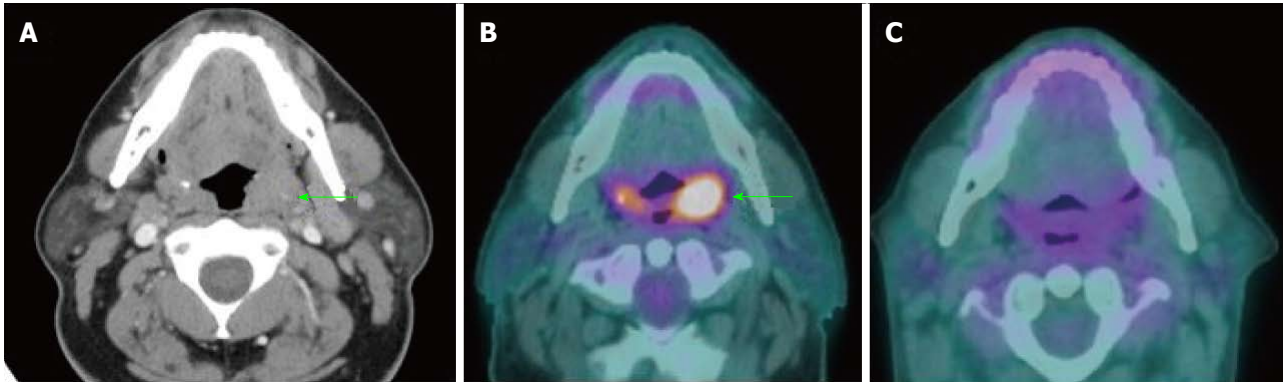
Complete treatment response at primary tumor site. Squamous cell carcinoma of the left palatine tonsil (arrows) was seen on contrast-enhanced CT (A) and pre-treatment PET/CT (B) with maximal SUV: 11.6. The tumor was no longer hypermetabolic on PET/CT with maximal SUV: 2.8 at 10 wk after treatment (C). PET/CT: Positron-emission tomography/computed tomography; SUV: Standardized uptake value.
